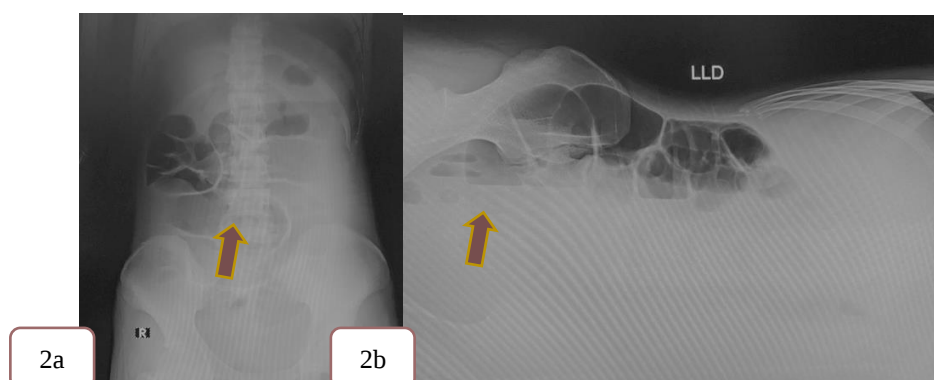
Decreased bowel gas left lumbar-pelvic region: suspected intussusception (X-Ray)
